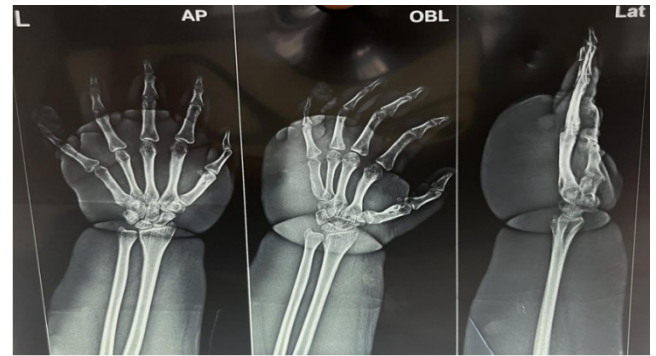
Anteroposterior, Oblique and Lateral X-ray of the left hand at 21 years of age
